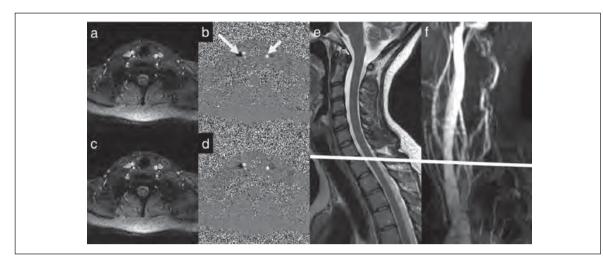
Cross-sectional cut through C7/T1 showing arteries and veins. (a) Magnitude component of phase contrast slice showing the cross-sectional anatomy of the neck at the C7/T1 level with vessels highlighted due to blood flow through the slice. (b) Phase component of phase-contrast MRI (PC-MRI) slice showing the direction and speed of flow by signal intensity. The bright signal indicates flow in the caudal-cranial direction, the expected arterial flow as shown in the left common carotid artery (short arrow), and the dark signal indicates flow in the cranial to caudal direction, the expected venous flow as shown in the right internal jugular vein (long arrow). (c) Magnitude image with manually outlined contours of the vessels of the neck and regions of low flow, such as muscle, to correct for any phase offset. (d) Phase image with the manually outlined contours and their enclosed phase intensity which can be used to quantify blood flow variables. (e) Sagittal T2 weighted image shows the bright signal of the cerebrospinal fluid with clear visualization of the vertebral column. This image may be utilized to indicate any narrowing of the cervical CSF signals and place the appropriate positioning of the PC-MRI slice (white localization line) at the C7/T1 neck level. (f) Sagittal 2D time-of-flight MR veno-graph projection shows the appropriate positioning of the PC-MRI slice (white localization line) perpendicular to the course of flow through the internal jugular veins.
